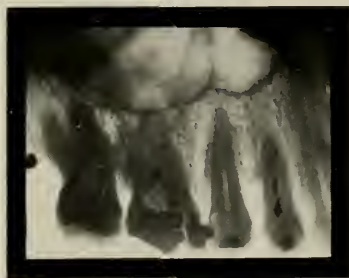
Wire passing to the distal through a perforation in the upper first molar. (Radiograph by Blum of New York City.)
